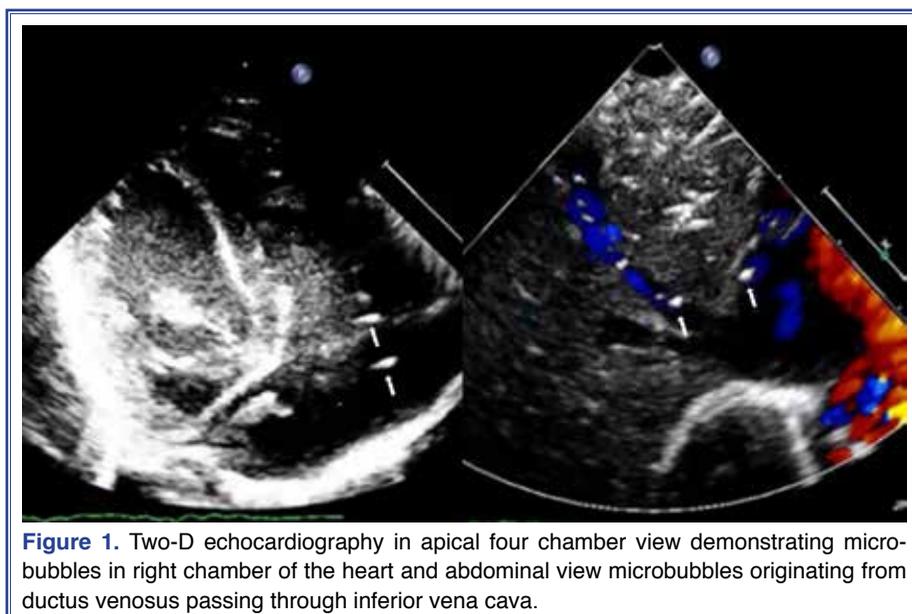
Two-D echocardiography in apical four chamber view demonstrating microbubbles in right chamber of the heart and abdominal view microbubbles originating from ductus venosus passing through inferior vena cava.
